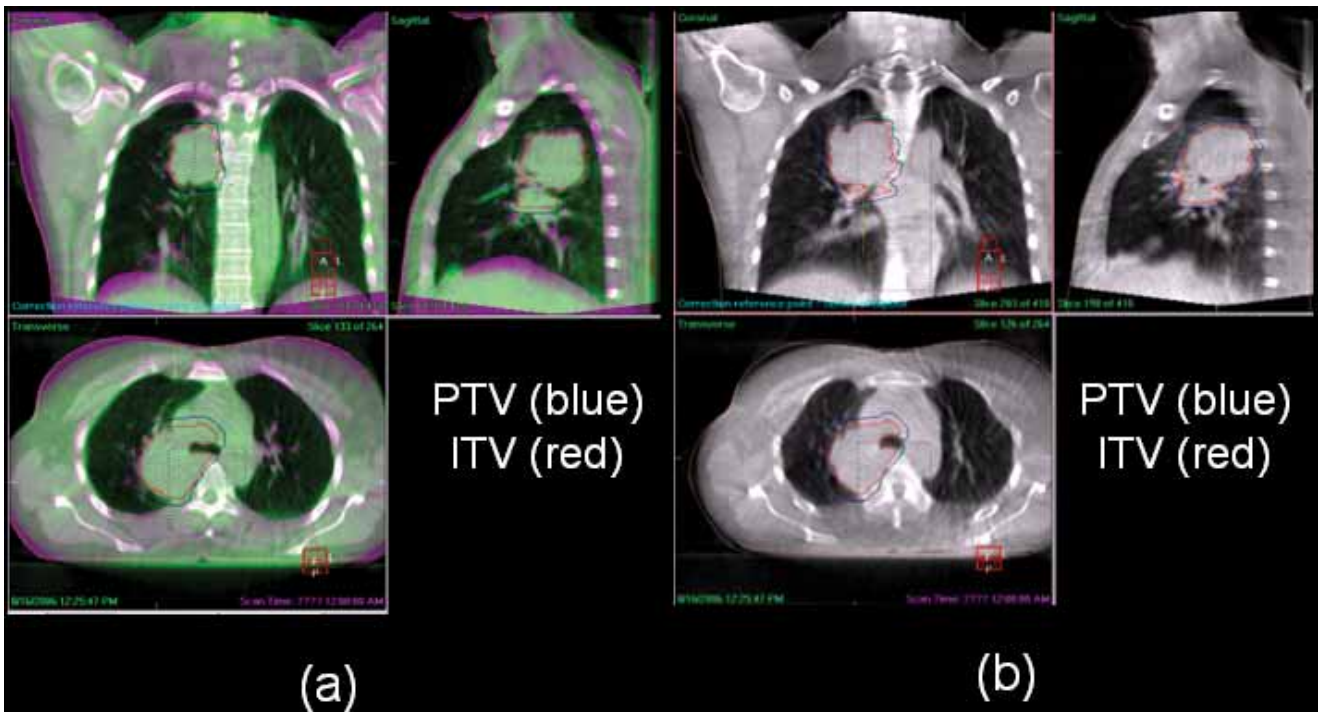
images showing the PTV and ITV in the 1st fraction: (a) VolumeView registered (shown in green) with the reference CT (shown in purple) for on-line treatment correction, (b) only the VolumeView image is shown after registration with the reference CT.
